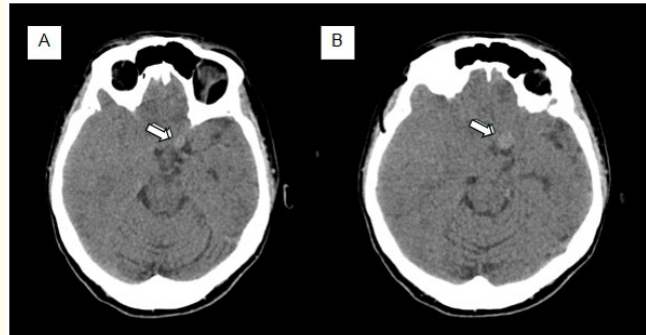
CT axial shows hyperdense extra-axial lesion supraclinoid left (A, B - arrow).
